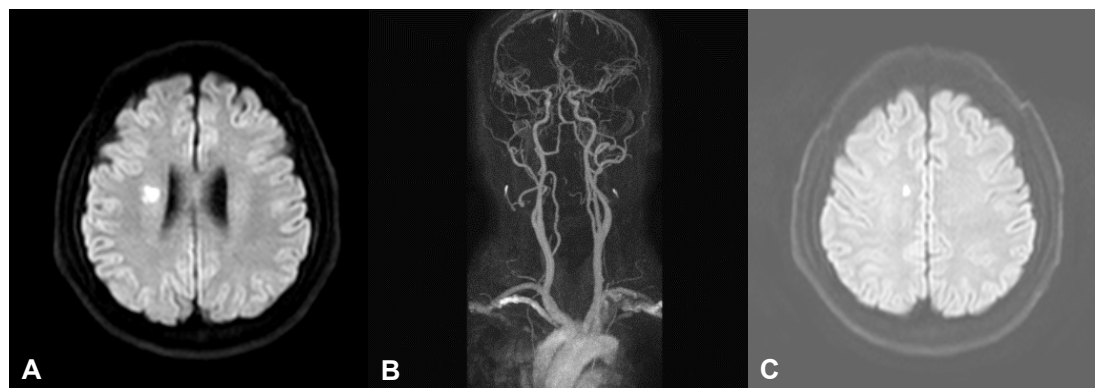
Brain MRI images. Initial diffusion-weighted MRI (A) showing restricted diffusion in the right corona radiata. MR angiography with gadolinium enhancement (B) was unremarkable. Follow up diffusion-weighted MRI (C) demonstrating a new area of restricted diffusion in the right high frontal lobe, which was not consistent with the patient's right hemiparesis.
